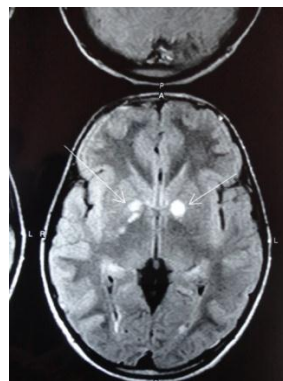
The patient's MRI showing the bright lesions marked with arrows.
